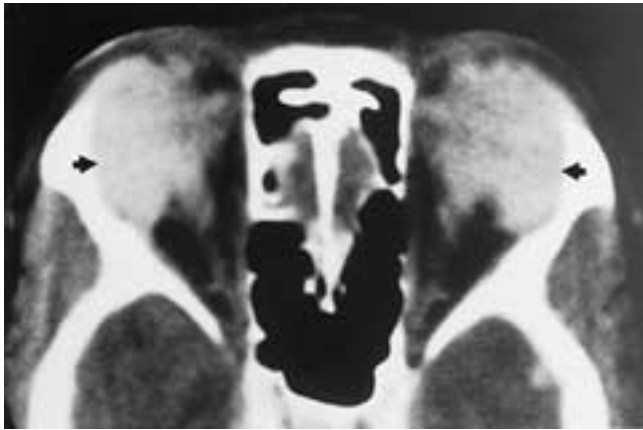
Sarcoidosis. Axial CT scan shows bilateral diffuse enlargement of entire lacrimal glands (arrows).
